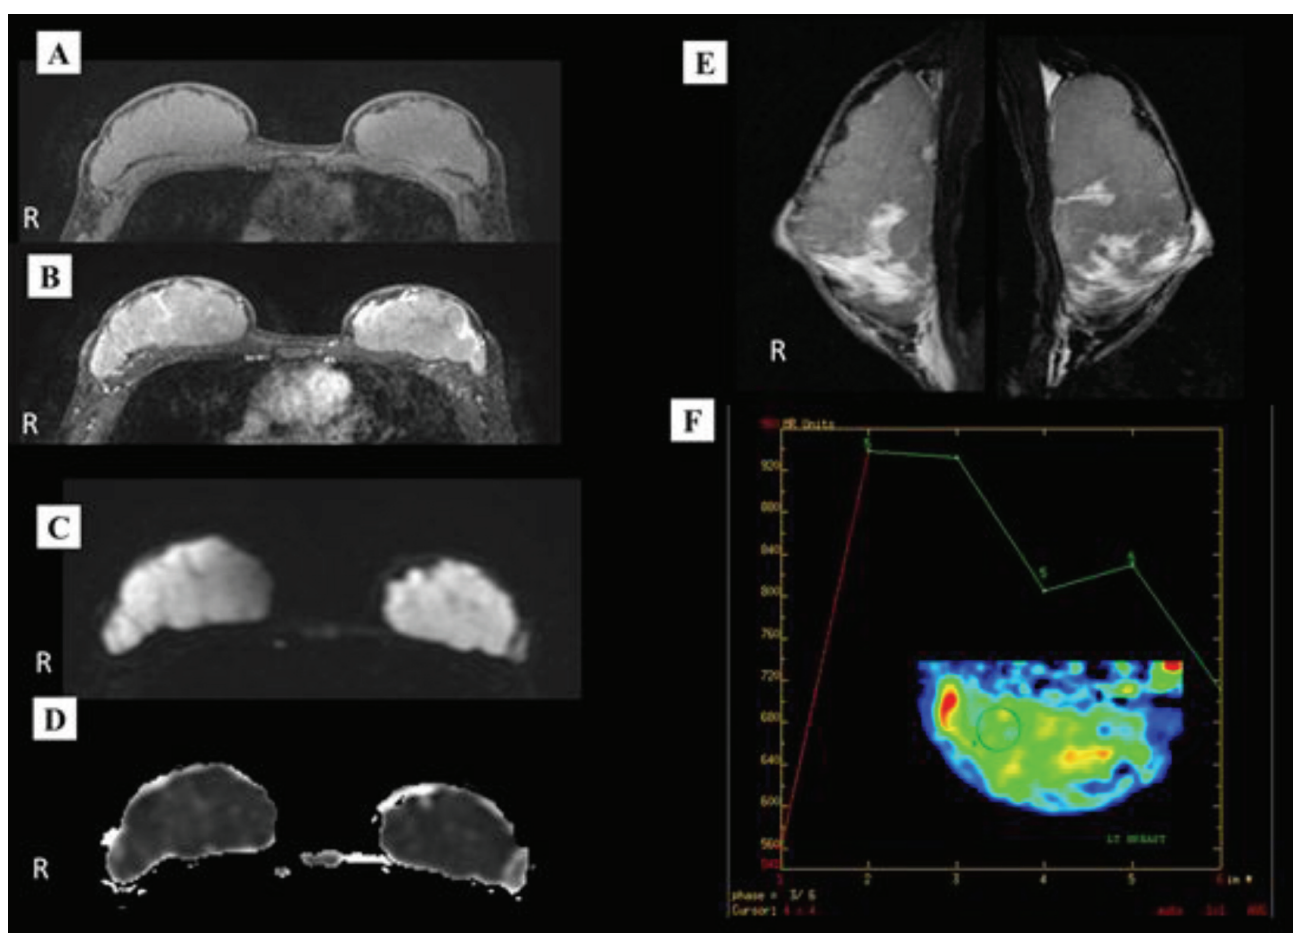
Precontrast axial T1W FAT-SAT image (A) demonstrated iso-intense lobulated masses that mostly occupied the entire breasts. Post-contrast axial T1W FAT-SAT image (B) revealed heterogeneous enhancement of the lobulated masses with enhancing internal septation. Diffusion weighted imaging (DWI) (C) and ADC (D) images demonstrated restricted diffusion. Precontrast sagittal T2W FAT-SAT image (E) showed the masses were predominantly in the upper quadrant with areas of hyperintensity in the lower quadrant suggestive of edema. Time-intensity curve of the mass at one of the regions of interest (ROI) (F) demonstrated rapid initial enhancement and washed out on the delayed phase (type III curve).
